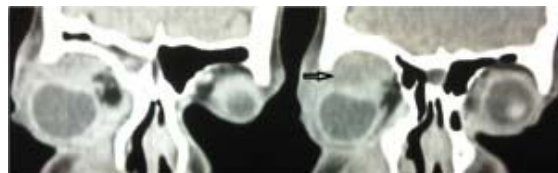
2 CT orbit Coronal view shows Haematoma in the superomedial aspect of right orbit
